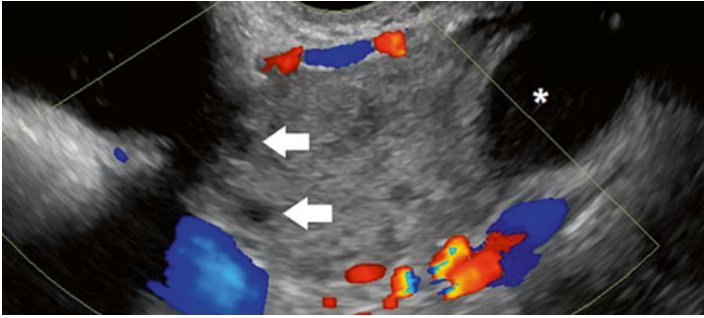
Peripheralized follicles. In a 26-year-old patient with laparoscopy-confirmed ovarian torsion, the ovarian follicles (indicated with *arrows*) appeared peripheralized by transvaginal ultrasound. No ovarian blood flow was documented by color Doppler. An ovarian cyst is denoted with an *asterisk* (\*)
